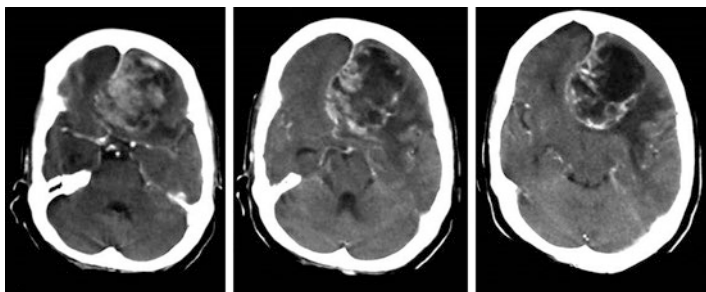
Contrast CT scan showing a left frontal irregularly enhancing tumor with solid and cystic components. This is the typical appearance for a high grade glioma usually glioblastoma
